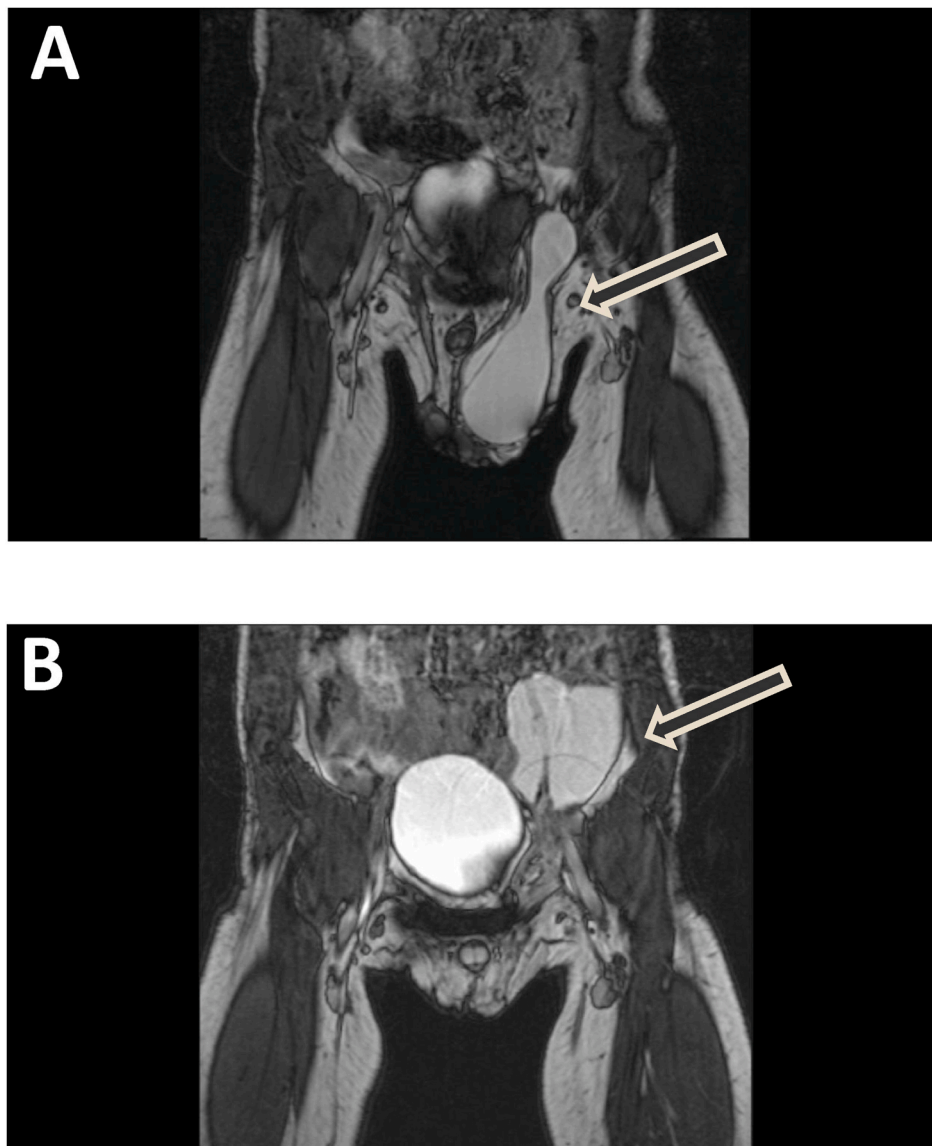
Abdominal MRI at the time of scrotal swelling and the time of non-scrotal swelling (A) MRI at the time of scrotal swelling displaying abdomen-scrotal connection of cystic lesion. Spermatic cord was seen in the cystic lesion. (B) MRI at the time of scrotal non-swelling after reducing the scrotal swelling by hand showing localized intraabdominal cystic mass located at retroperitoneum.
